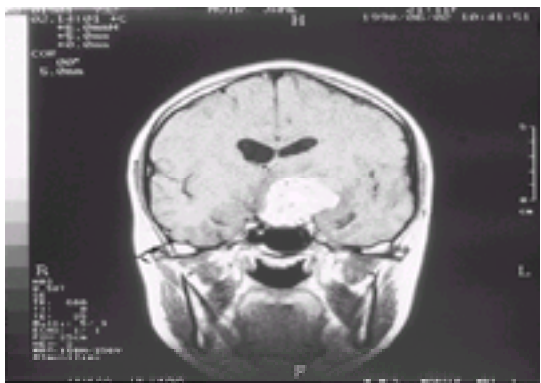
MRI to show an intrinsic (glioma) tumour of the thalamus and hypothalamus. The vessels of the circle of Willis contain (gadolinium) contrast material. The temporal horns are seen (as black) on either side.
